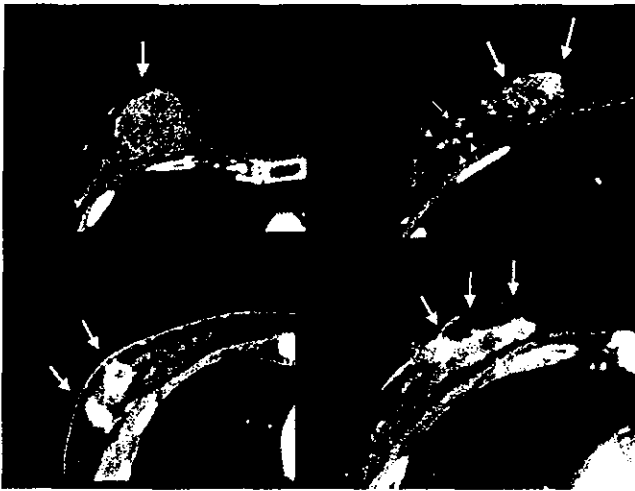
Localized tumor type (left upper) and diffuse type: tumor and spots (right upper), multiple spots (left lower), and glandular spreading type (right lower) by CE-CT.
